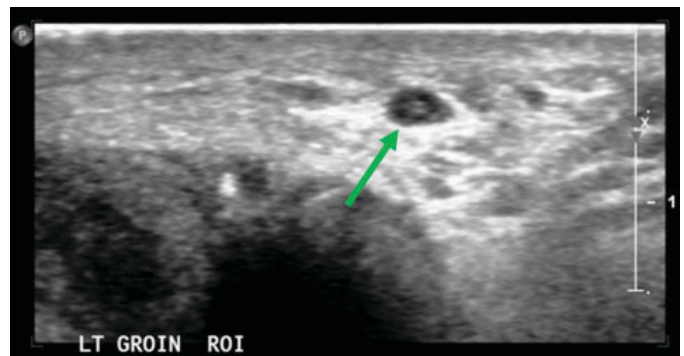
Ultrasound of left groin demonstrating 3 mm hypoechoic structure.
